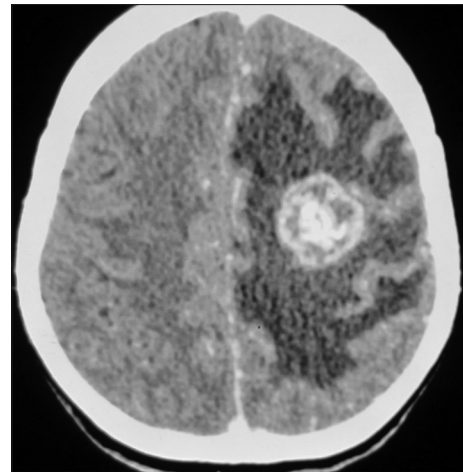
CT scan (axial view) showing a lesion of 3.4 cm × 2.4 cm in size with well-defined margins. The lesion is strongly enhancing inhomogenously on contrast administration, with surrounding perifocal edema and mass effect
